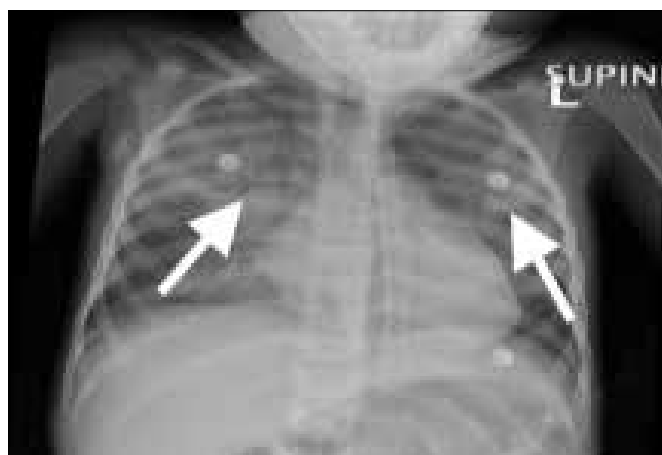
Frontal chest X-ray showing alveolar infiltrates (white arrows) bilaterally consistent with alveolar haemorrhage. (Courtesy of Dr D Parris, Department of Paediatrics and Child Health, Steve Biko Academic Hospital)
